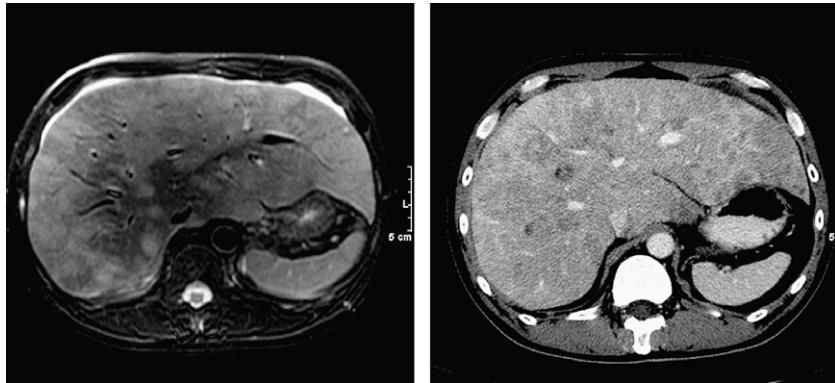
CT versus MRI of same lesions showing apparent ‘progression’ due only to differing method of measurement.
